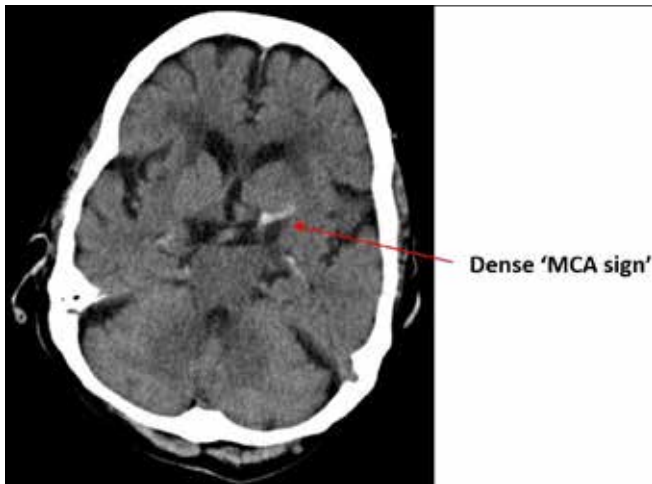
Unenhanced CT head demonstrating a hyperdense left middle cerebral artery (MCA) consistent with an acute thrombus within the left MCA. This radiological sign is known as the 'dense MCA sign'.
